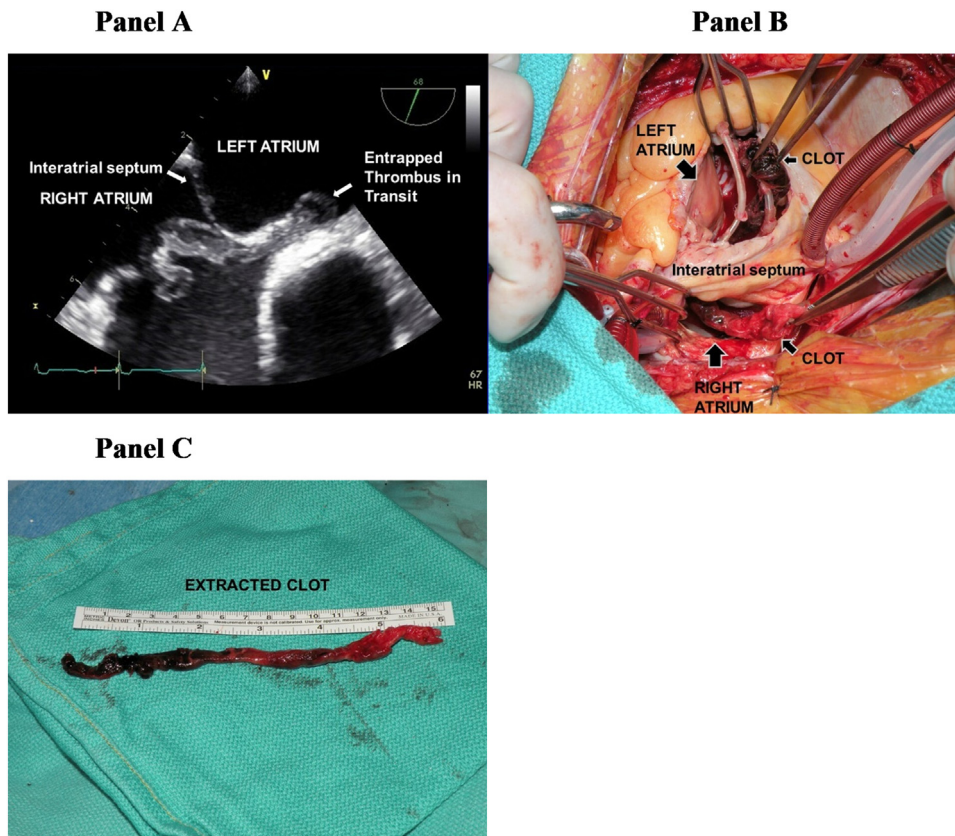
Caption: An entrapped thrombus in transit, visualized with transesophageal echocardiography (Panel A), was found to be extending from the right atrium into the left atrium through a patent-foramen-ovale during surgical exposure (Panel B) and was extracted in its entirety (Panel C).
